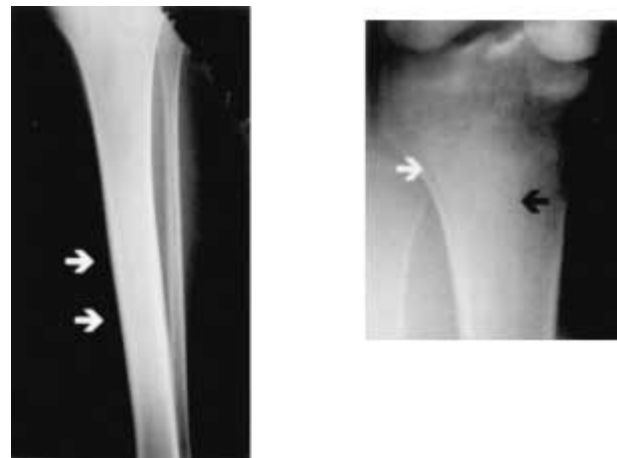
Xrays demonstrate intramedullary sclerosis (arrow heads) without cortical reaction in two cases (a: tibial diaphysis in a 16-year-old patient, no history of trauma, b: Proximal tibial metadiaphysis in a 31-year-old patient, with a history of a ski accident 3 months prior to presentation. Xrays at the time were completely normal).
